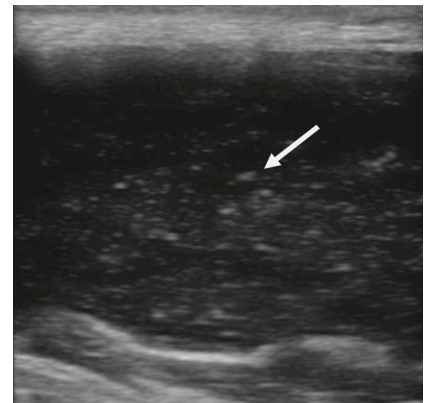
Ultrasonographic changes in abscess
